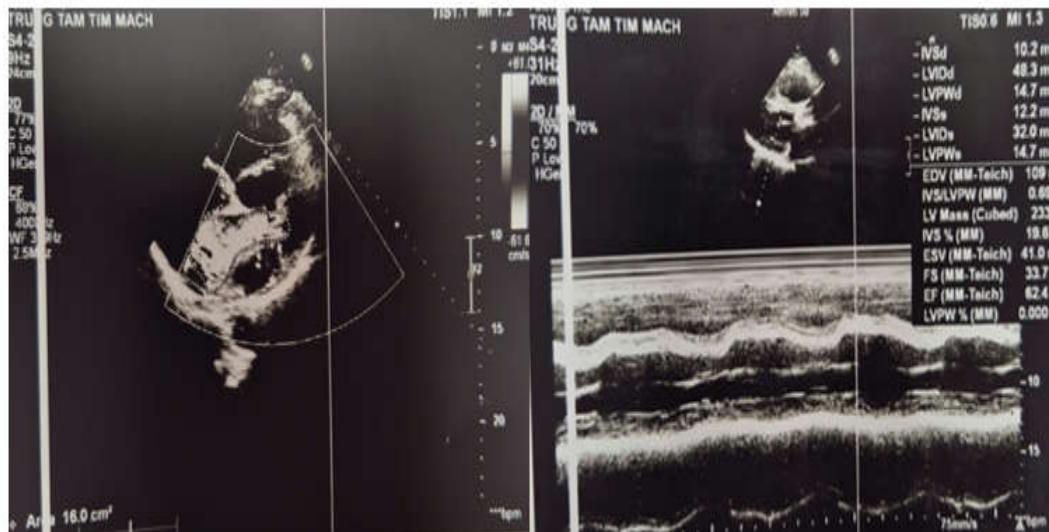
Preoperative echocardiography showing severe mitral regurgitation (regurgitant area 16 cm², LVEF 62%)
